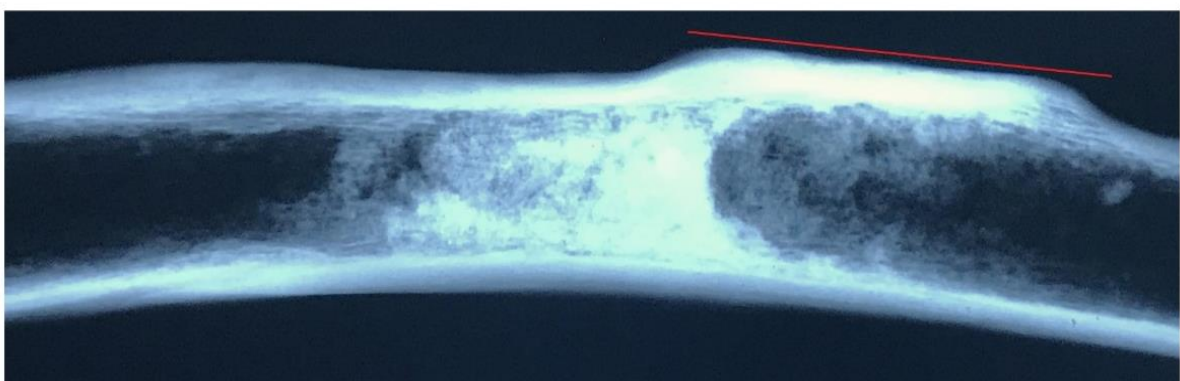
Bone surface anatomic morphology and X-ray image reveal that a flat splint of rigid material was used to orthopaedically support the injured limb at the locus of fracture.
